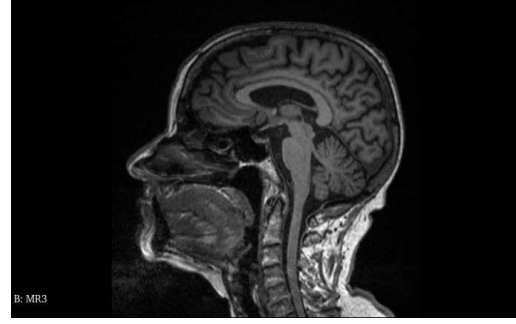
A slice of MR image from sagittal view
